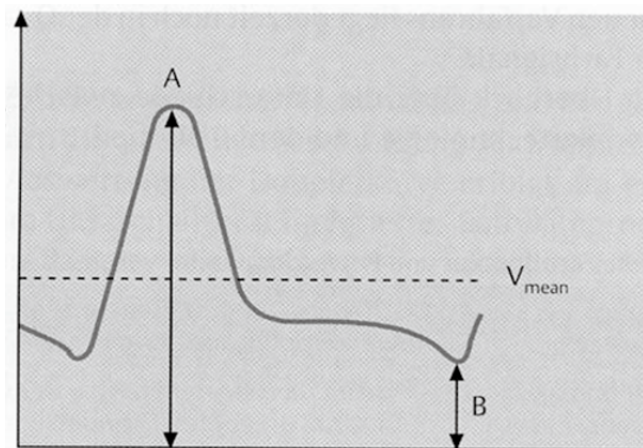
Calculation of Doppler indices [PI = (A-B)/V_{mean}].
